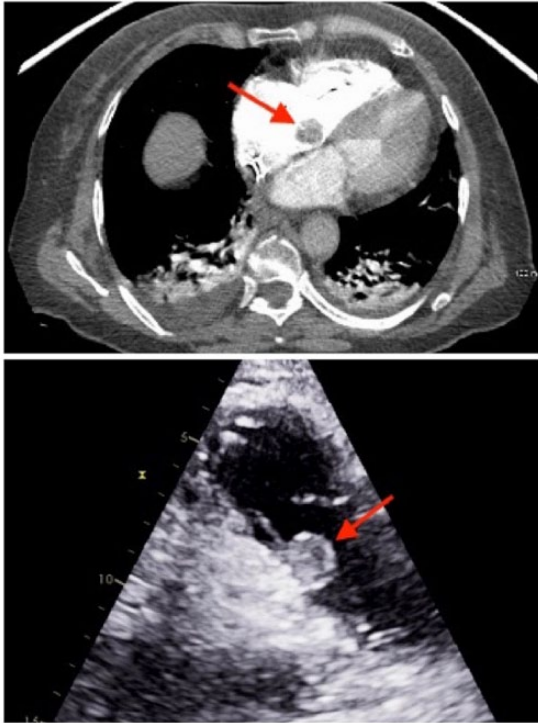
Computed tomographic scan of chest and 2-dimensional transthoracic echocardiographic images showing a 2.5-cm² sessile mass attached to the inferolateral wall of the right atrium indicated by arrow.
